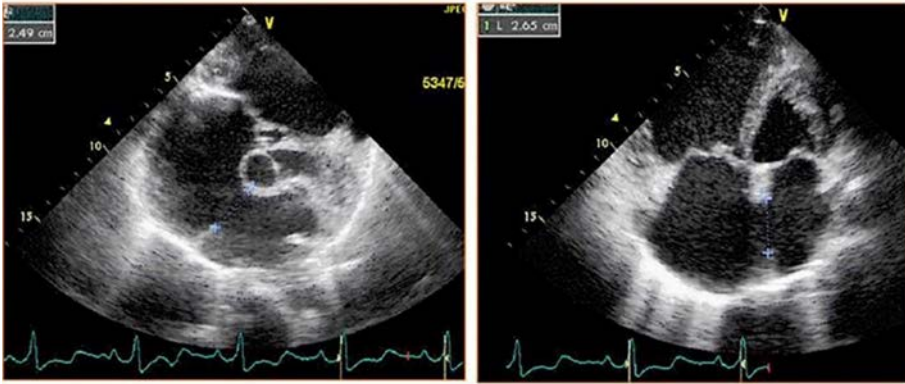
Secundum ASD. This young patient presented with right heart failure symptoms at 18 years of age. Clinical examination revealed a systolic murmur. A chest X ray showed cardiomegaly. Transthoracic echocardiogram clearly shows a haemodynamically significant shunt that was very large. The ASD was deemed too large for percutaneous closure and thus surgical closure was recommended. A contrast CCTA (not shown) was carried out prior to surgery that did not show any evidence of coronary abnormalities.
